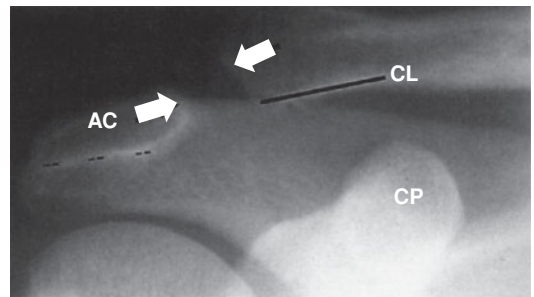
Acromioclavicular joint. The anteroposterior radiograph shows a normal adult shoulder. The acromioclavicular ligament (arrowhead) and the coracoclavicular ligament (\*) are shown. AC, acromion; CL, clavicle; CP, coracoid process.
